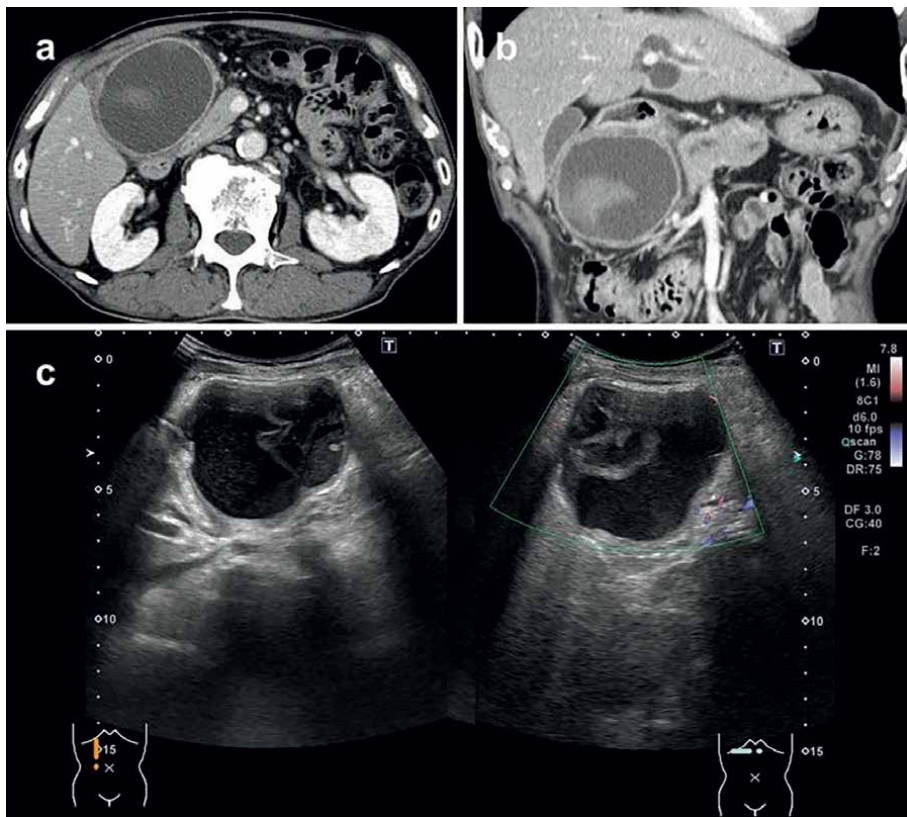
Retention cyst of HP in the duodenum (figure). Contrast-enhanced CT scan (a, b) and U/S (c) revealed a cyst that has reached to 6 cm due to intra-lesional hemorrhage [57].
